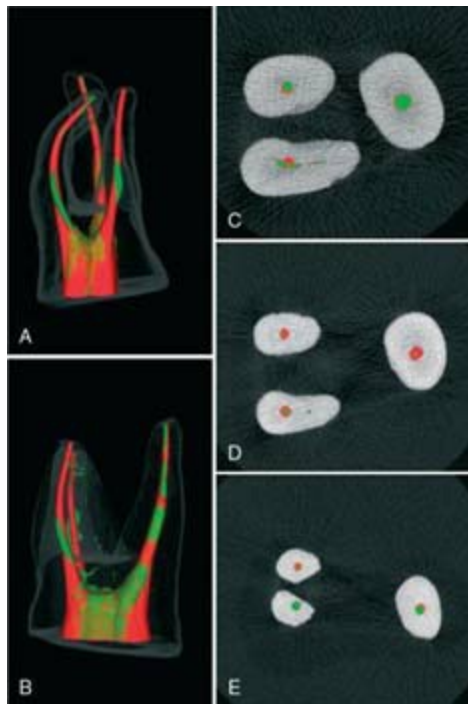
Example of a desired shape, with the original root canal fully incorporated into the prepared outline. A–B, Micro-computed tomography reconstructions in clinical and mesiodistal views of a maxillary molar prepared with a NiTi rotary system. The *green area* indicates the pretreatment shape, and the *red area* indicates the posttreatment shape. Areas of *mixed red and green* indicate no change (i.e., no removal of radicular dentin). C–E, Cross sections of the coronal, middle, and apical thirds; the pretreatment cross sections (*green*) are encircled by the posttreatment outlines (*red*) in most areas.
